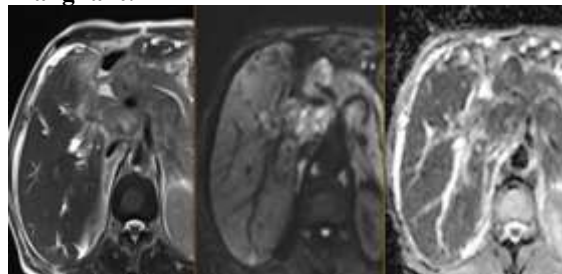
Axial t2 sequence shows abrupt narrowing of distal CBD with asymmetric circumferential mural thickening with associated exophytic soft tissue component corresponding DWI and ADC images shows obvious diffusion restriction.
